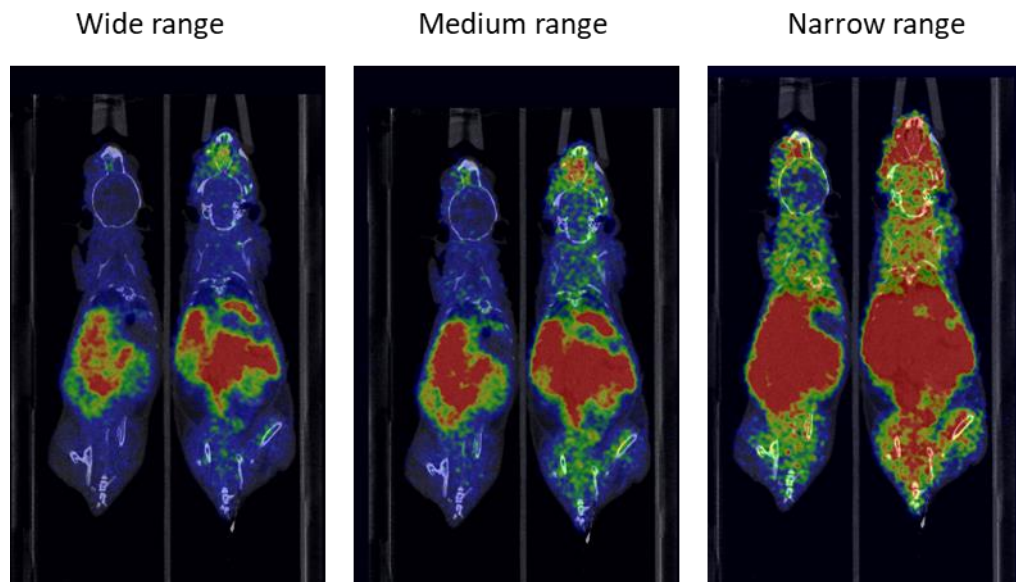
Screenshots of the visualization of PET/CT images with different scaling ranges. The scaling range should be carefully chosen in order to differentiate tumors from surrounding non-tumor tissues.
